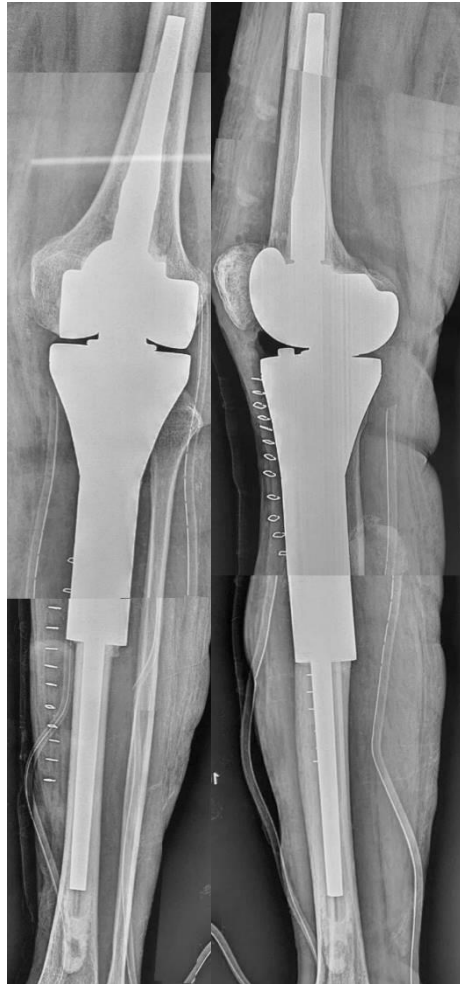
Postoperative stitched X-ray showing left modular hinged long-stem knee endoprosthesis*
